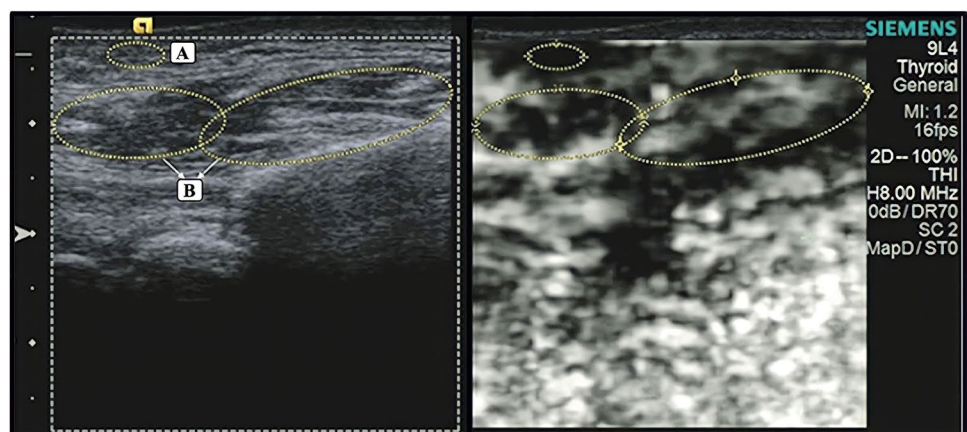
Thickness (A) and width (B) measurements of masseter muscle on ultrasonography
